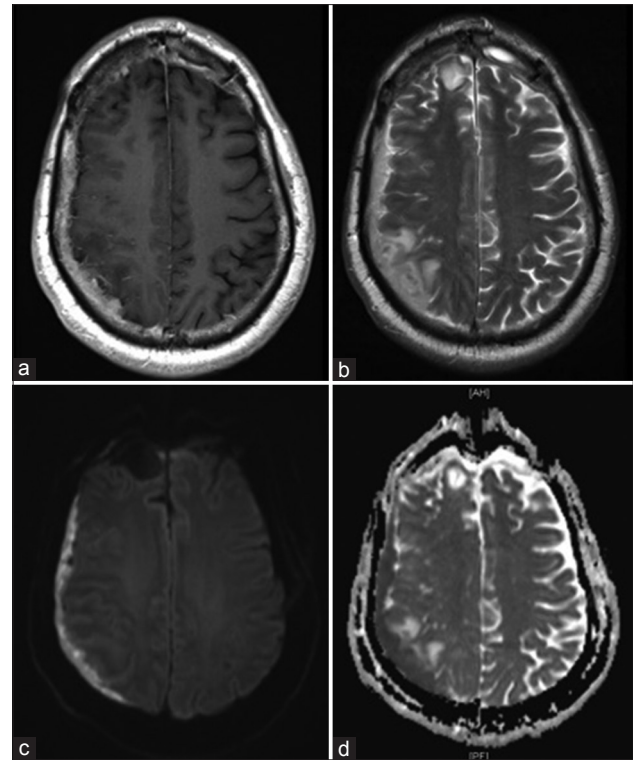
(a) MRI with contrast; (b) MRIT2WI; (c) DWI; (d) ADC. MRI Head demonstrating right frontoparietal subdural collection with associated vasogenic edema and restriction on DWI and ADC maps
